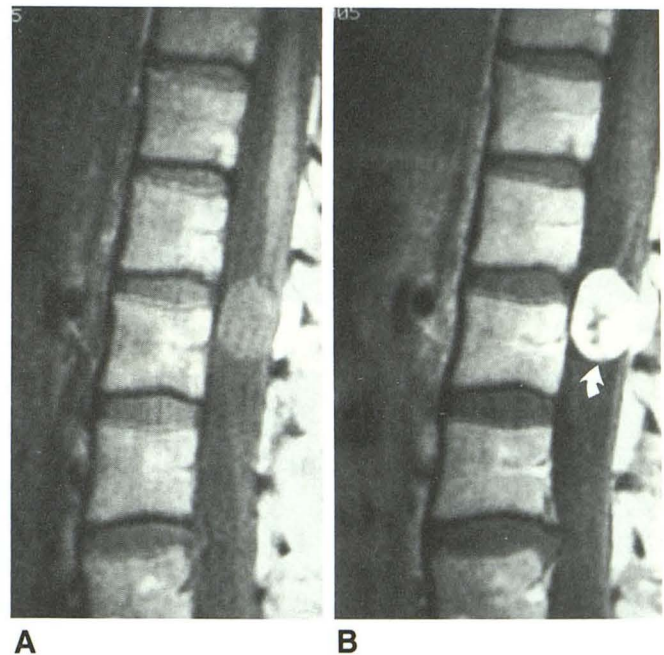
A and B, Schwannoma. Compared with pre-Gd-DTPA 800/20/2 MR image (A), the post-Gd-DTPA 800/20/2 MR image (B) shows 350% increase in signal intensity in the tumor (arrow).
